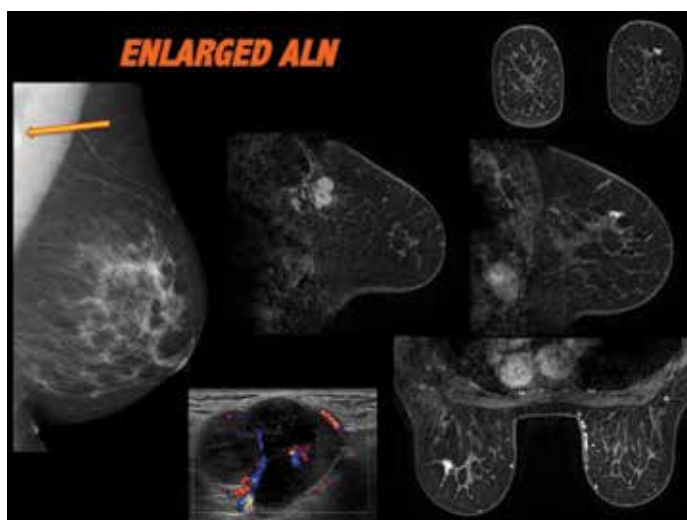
BIRADS B mammographic density, standard 2D MMG reveals abnormal left axillary lymph node, which appears of matted nodal mass configuration on ultrasound. Malignant on fine needle biopsy, suggestive of breast primary origin. No breast abnormality perceived on mammogram or ultrasound. MRI reveals small stellate left breast upper outer quadrant, confirmed as malignant on biopsy. Outcome: 17mm invasive lobular carcinoma grade 2 & LCIS, ER/PR +, 20/20 LN positive.
